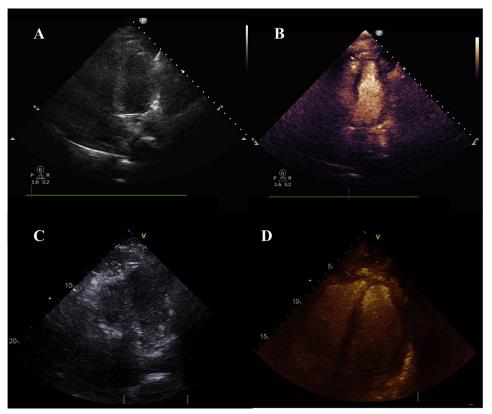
Diagnostic utility of contrast-enhanced echocardiography in patients with COVID-19. Patient 1: unenhanced attempted four-chamber view with poor left ventricular endocardial border definition (A). Contrast-enhanced four-chamber view with adequate opacification of the left ventricular cavity and excellent endocardial border definition (B). Patient 2: unenhanced attempted four-chamber view with poor left ventricular and right ventricular visualization (C). Contrast-enhanced four-chamber view with adequate opacification of both left and right ventricules (D).
